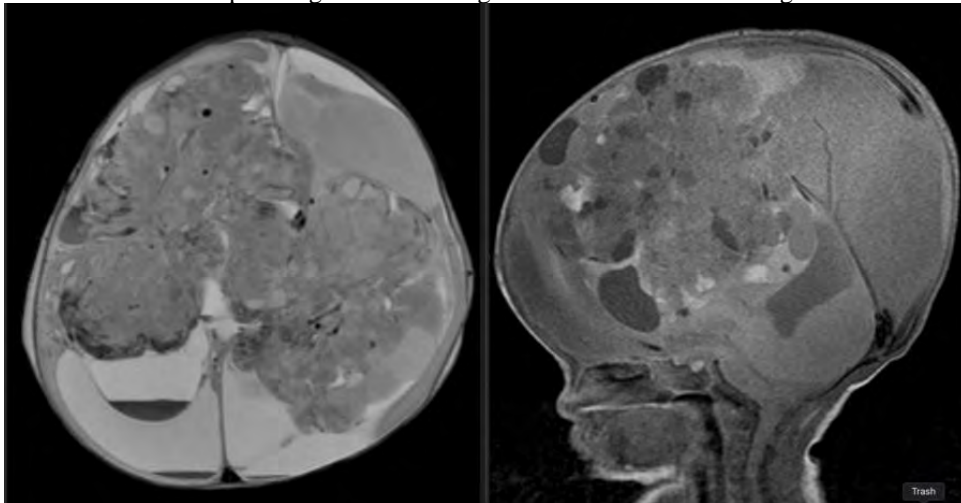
(Left) Axial T2-weighted MR image of the newborn head shows a 1.1 x 1.2 x 1.3 cm heterogeneous solid and cystic mass with multiple fluid bright cystic structures and massive obstructive hydrocephalus. (Right) Sagittal T1-weighted MR image of the newborn head.
